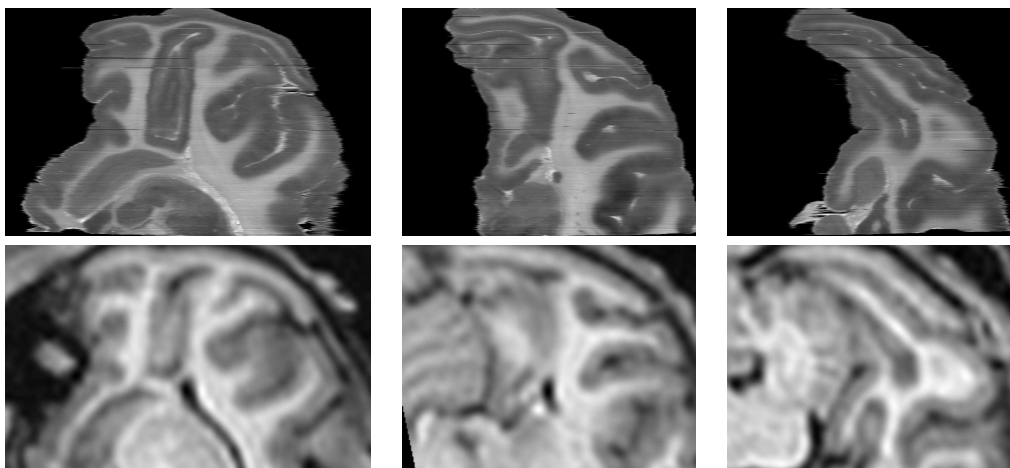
Fusion loop # 3. From left to right: one axial and two sagittal slices. First row: autoradiographic volume after smoothing of the 2-D transformation. Second row: MR image resampled after affine registration against the above reconstructed AR volume.
